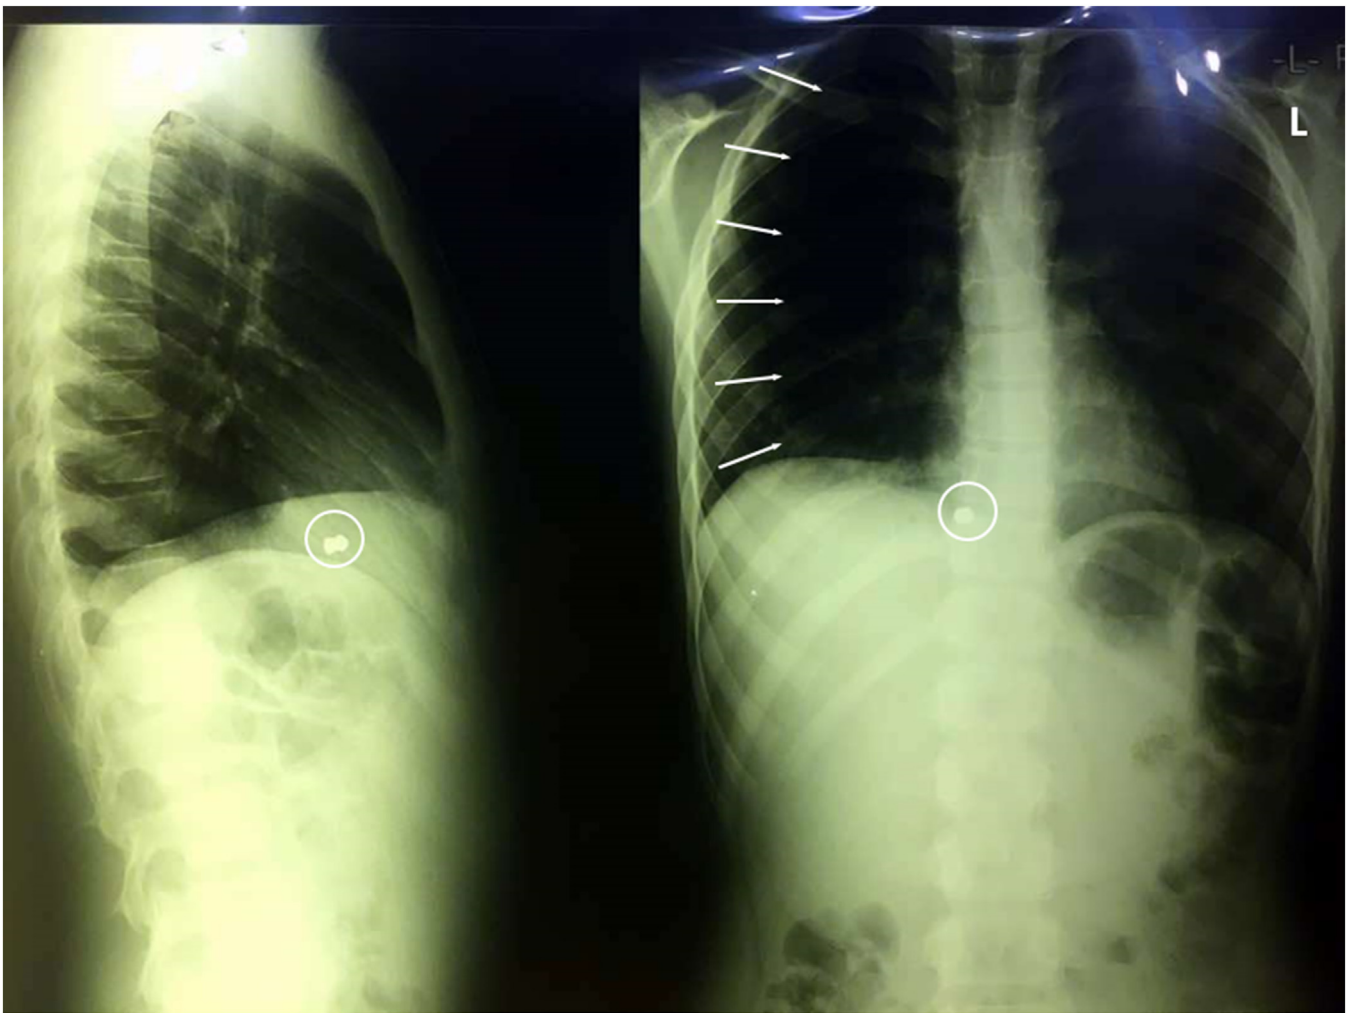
The primary chest x-ray showing the visceral pleural line (arrows) because of right-side pneumothorax and the air gun bullet inside the middle mediastinum (circle).
